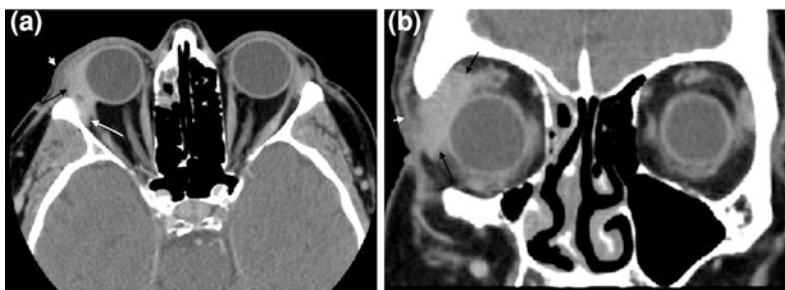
A- 43-years-old female patient with orbital pseudotumour involving the lacrimal gland. a–b Axial and coronal contrast enhanced CT images reveal enlargement of the right lacrimal gland (arrows) with stranding of the preseptal fat (arrow head) suggestive of dacryoadenitis. The patient showed a favorable response with steroid therapy
